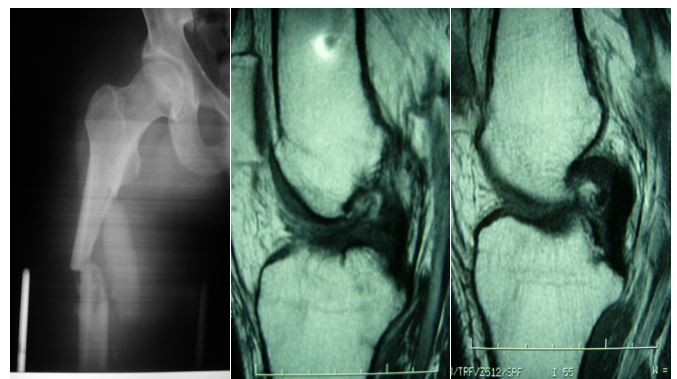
Patient with diaphyseal femoral fracture after a high-energy accident (A). Eight months after the fracture, ipsilateral knee MRI was performed when the patient complained of knee instability. The absence of ACL (B) could be observed, suggesting chronic tearing (C). A bone-tendon-bone ACL patellar tendon autograft reconstruction was performed 1 month after diagnosis of the ACL tear.
